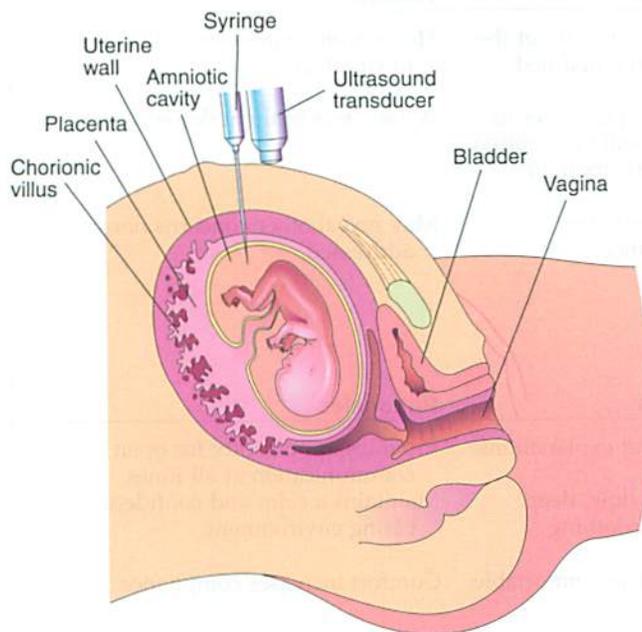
Amniocentesis. The woman is scanned by ultrasound to locate the placenta and determine the position of the fetus. A needle is inserted through the skin, fascia, and uterine wall, away from the placenta and body of the fetus. When the needle is within the uterine cavity, amniotic fluid is withdrawn.
